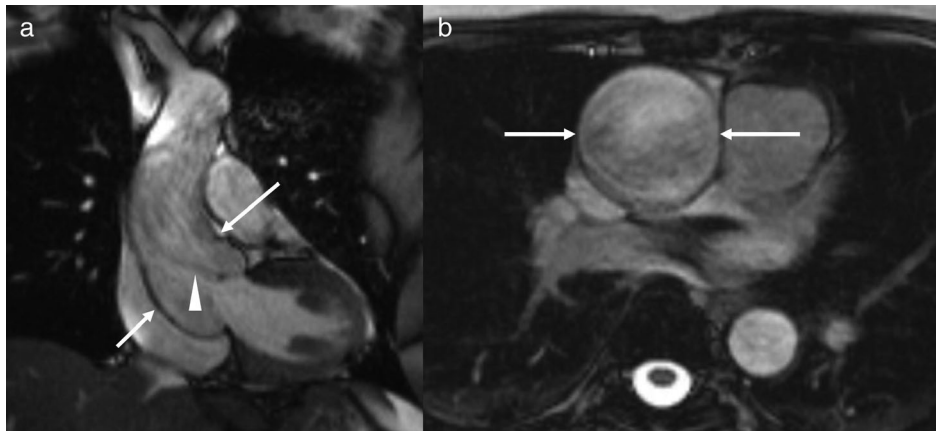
Cine bSSFP MRI of bicuspid aortopathy in a 56-year-old woman. Oblique coronal cine bSSFP (a) and transaxial bSSFP single-shot (b) MR images demonstrate an ascending thoracic aortic aneurysm measuring up to 5 cm, with effacement of the sinotubular junction (arrows). There is aortic stenosis, as evidenced by a mild stenotic flow jet (arrowhead), in keeping with bicuspid aortic valve and associated aortopathy. She did not undergo surgical repair at the time of imaging, and subsequently presented acutely 10 months later with a ruptured Type A aortic dissection requiring emergent surgical repair.
